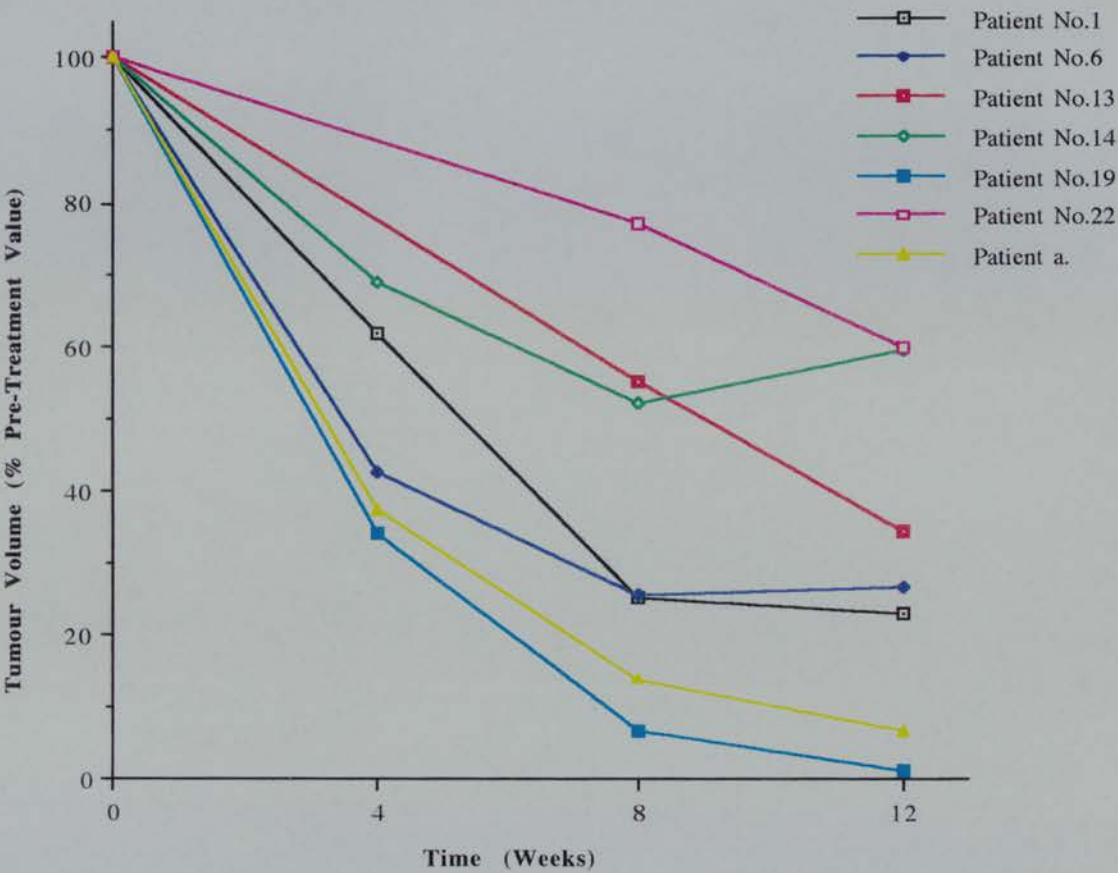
shows individual response curves for the seven tumours treated with tamoxifen as part of the Trial of Primary Systemic Therapy. Tumour volumes were assessed by serial ultrasound scans and related to the pre-treatment volume to measure response. Patient numbers refer to previous tables of clinical data presented for patients recruited to the trial.
